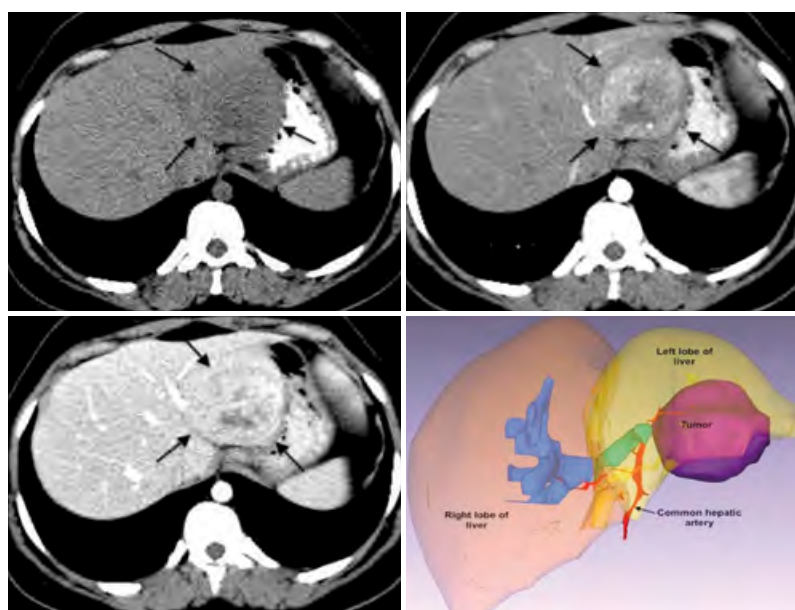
Axial CT scans of abdominal organs (tumor nodule is arrowed): a – native phase, b – post-contrast image, hepatic arterial phase, c – arteriovenous phase, d – 3D model of the liver highlighting the tumor, unchanged parenchyma of the right and left lobes and branches of the hepatic artery and hepatic portal vein.
